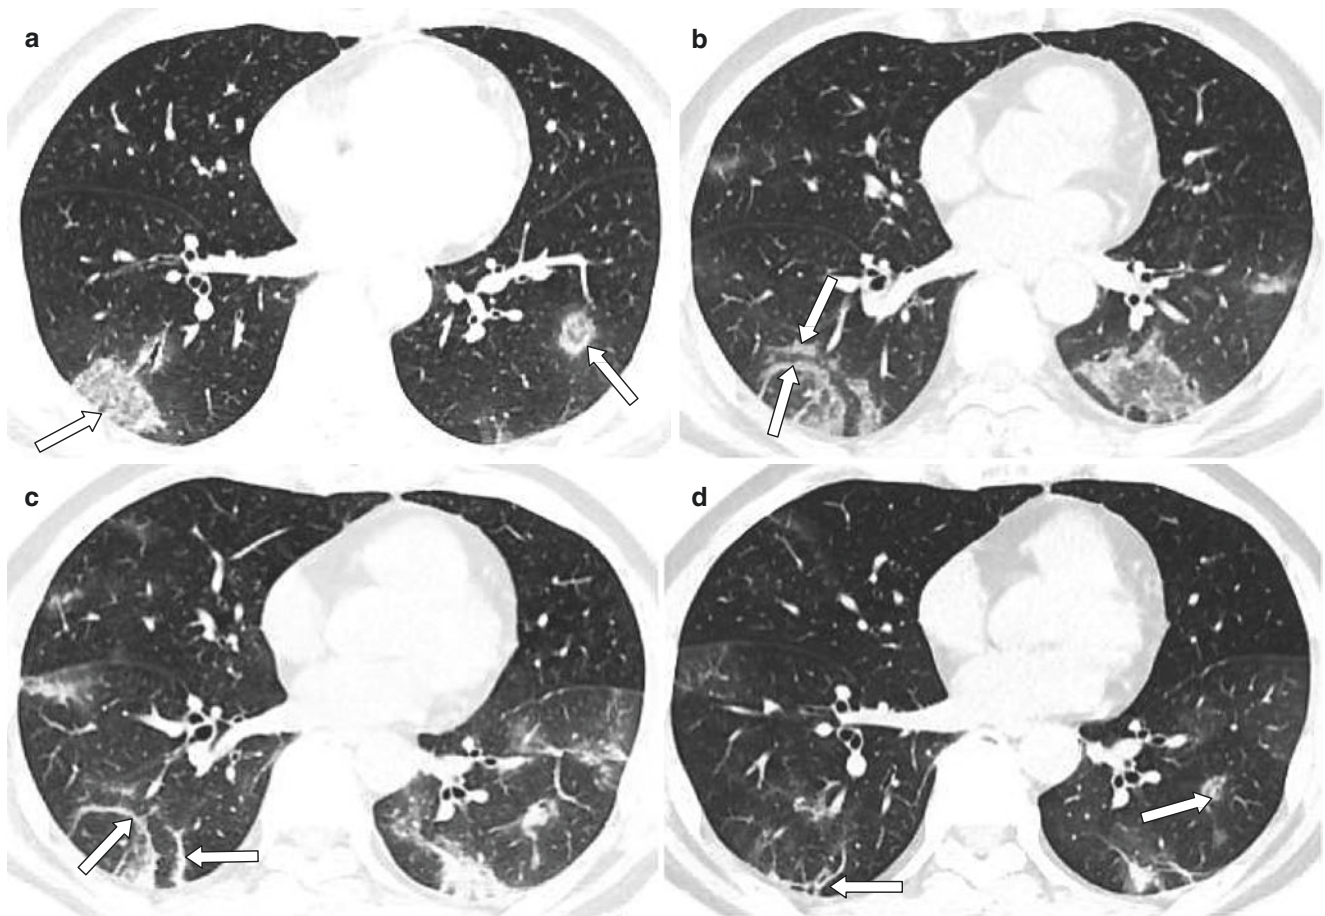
(a, b) A 71-year-old female patient. CT scans show multiple ground-glass opacities and reticular pattern, accompanied by pleural effusions
